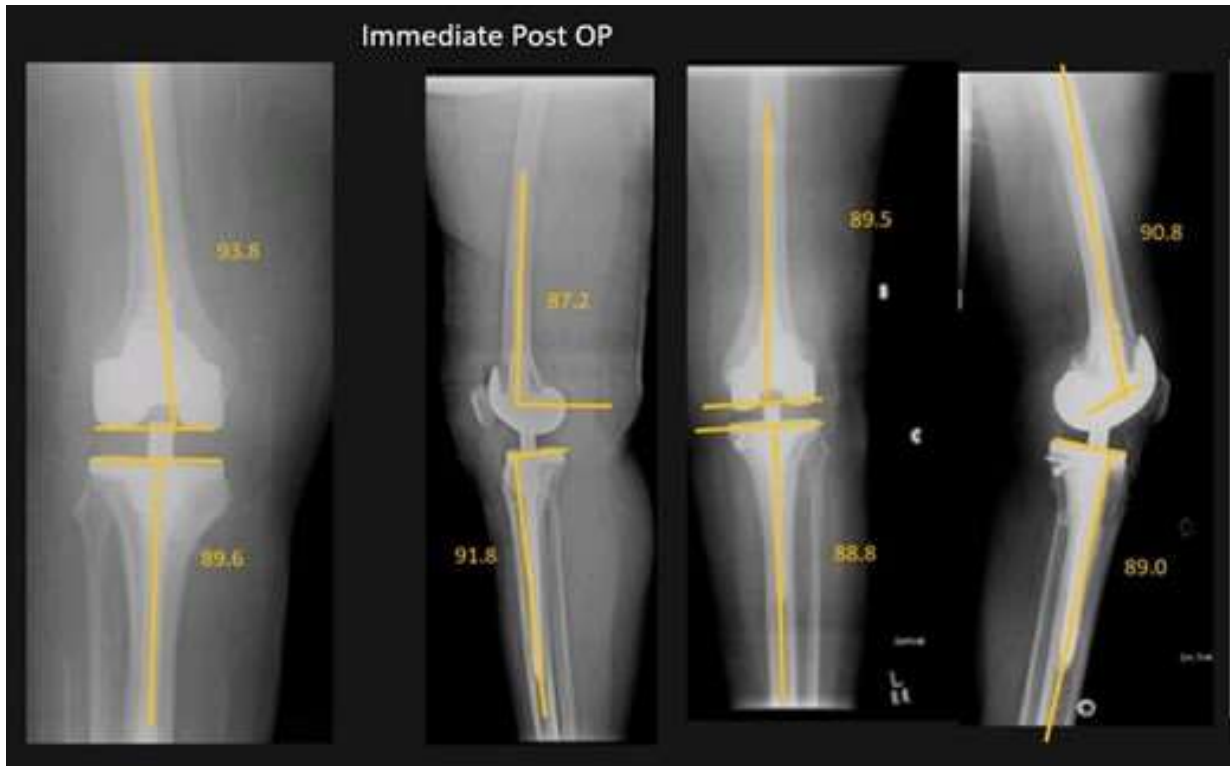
Following a revision arthroplasty, immediate postoperative radiographs
